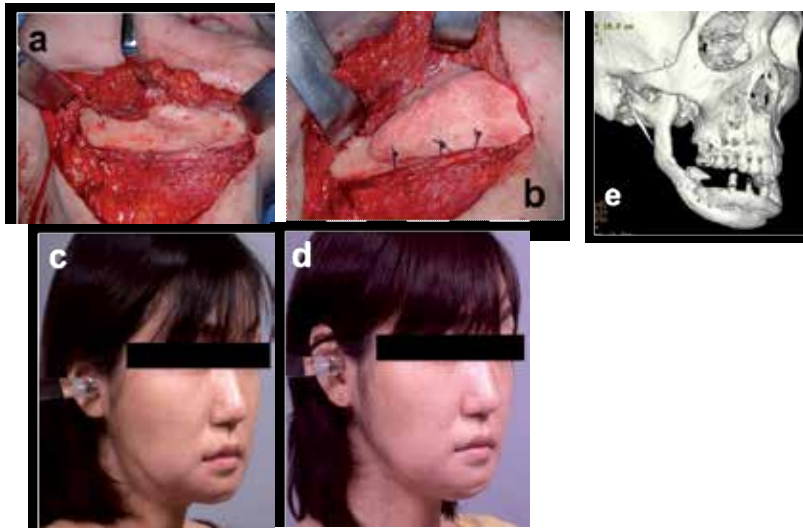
Case2 a, b: During operation c: Facial appearance before surgery d: Facial appearance at 1 year after surgery. e: 3D CT image of the left lower jaw after surgery
